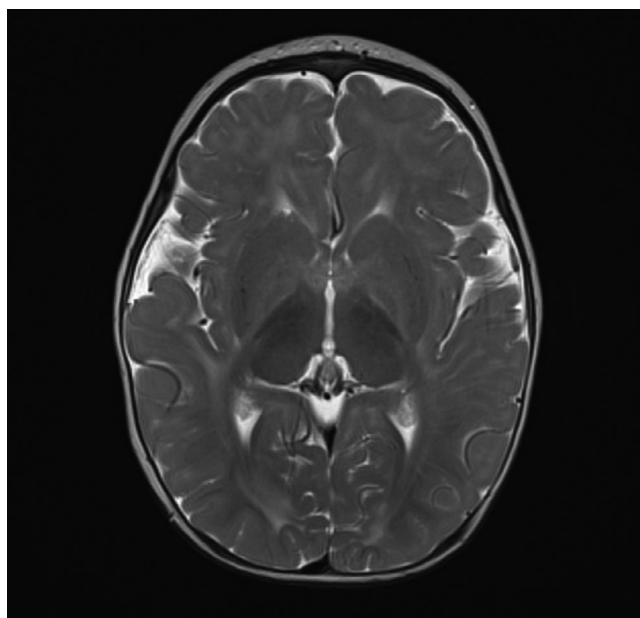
Brain MRI showing extensive white matter changes
